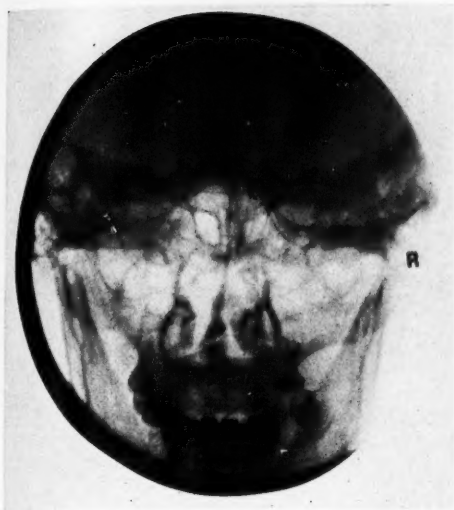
Radiograph showing chronic hyperplastic sphenothmoiditis on the right side.
